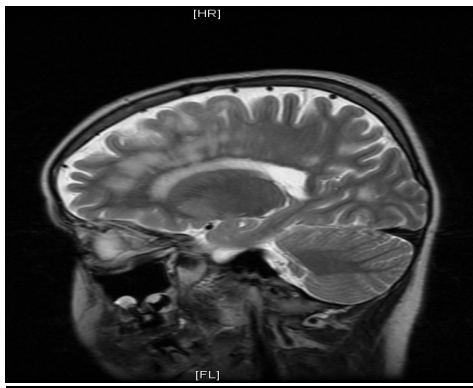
(a): MRI of the Brain T2 Sequence Sagittal View Showing Hyperintensities in the Cerebral White Matter
